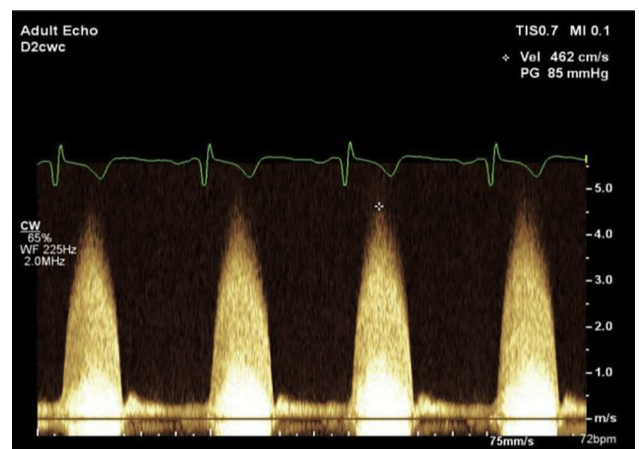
Continuous wave Doppler using a Pedoff transducer placed in the suprasternal view on transthoracic echocardiography demonstrated a very high velocity (4.6 m/sec) and gradient (85 mm Hg) along the beam of the transducer, which is suggestive of severe stenosis.
